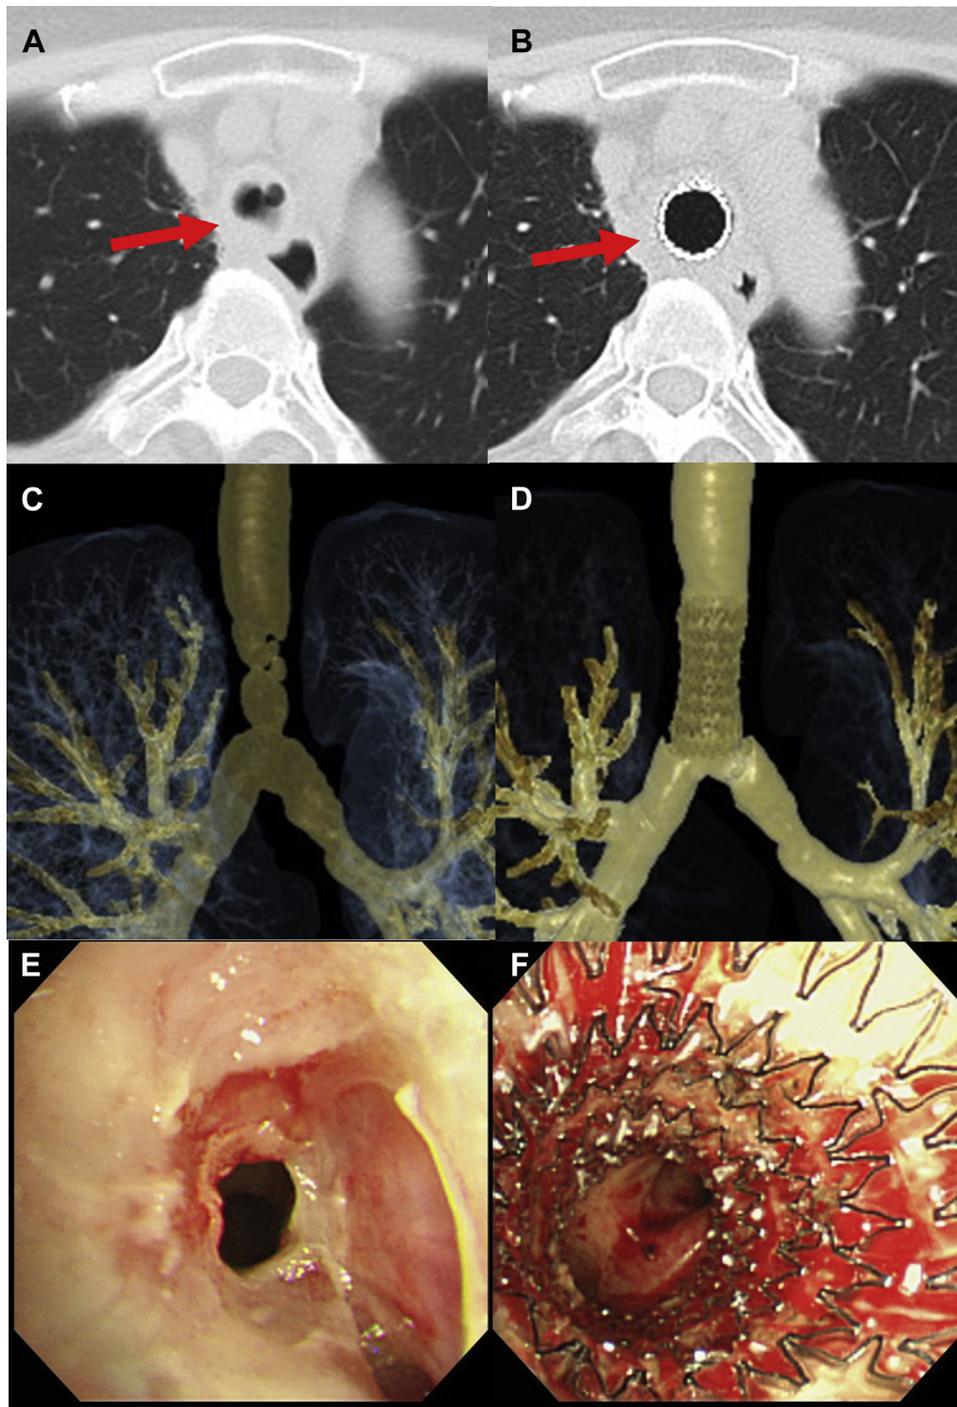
(A) Chest computed tomography (CT) image showing the tracheal stenosis before stenting (arrow), (B) chest CT image showing improvement of the tracheal stenosis after stenting (arrow), (C) three-dimensional CT coronal reconstruction image before stenting, (D) three-dimensional CT coronal reconstruction image after stenting, (E) bronchoscopic view of the trachea showing the stenosis, and (F) bronchoscopic view of the trachea after stenting.
